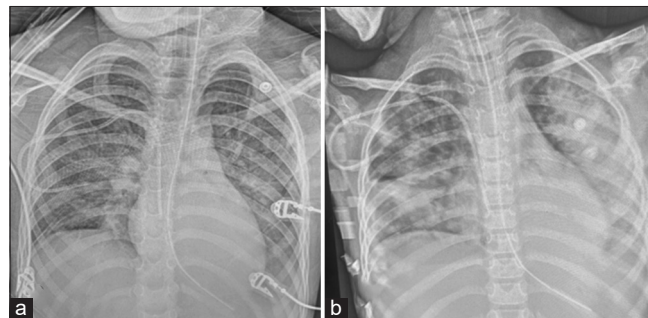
(a and b) Chest X-ray diffuse interstitial infiltrates and pleural effusion
